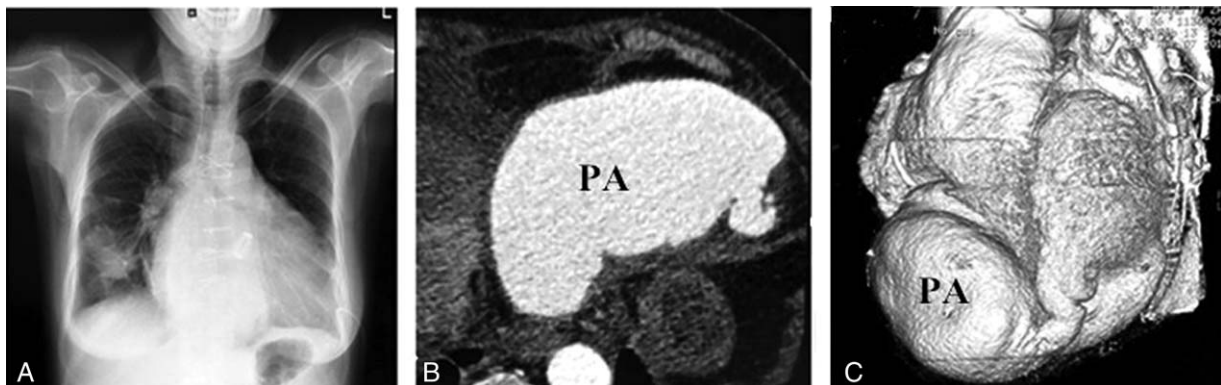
Patient no. 7. (A) Chest X-ray shows an enlarged heart and encapsulated effusion in the right lung. (B) CTA reveals a narrow neck and a giant pseudoaneurysm. (C) CT reconstruction shows an optimal visualization of pseudoaneurysm. CTA=computed tomography angiogram, PA=pseudoaneurysm.
